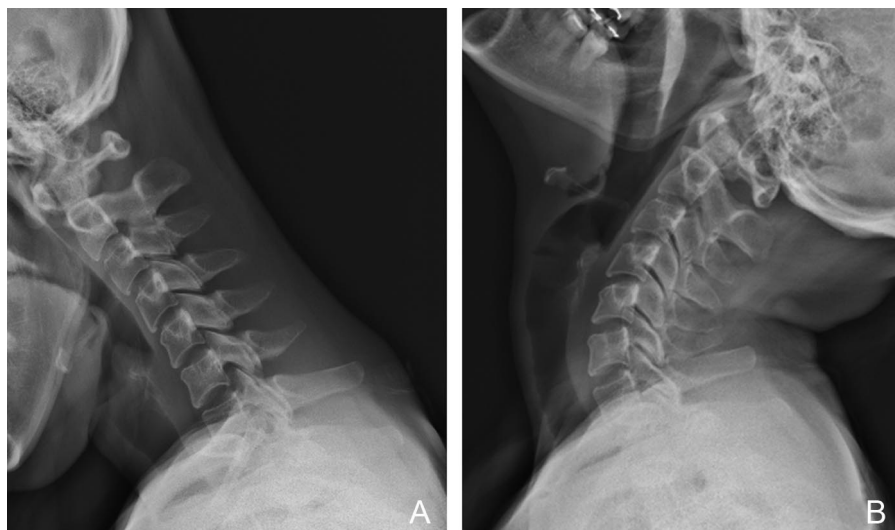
Lateral view radiograph of the cervical spine in (A) flexion and (B) extension. The separating and gathering of spinous processes during flexion and extension only occur in the cervical spine and cannot be observed at the cervicothoracic junction.
